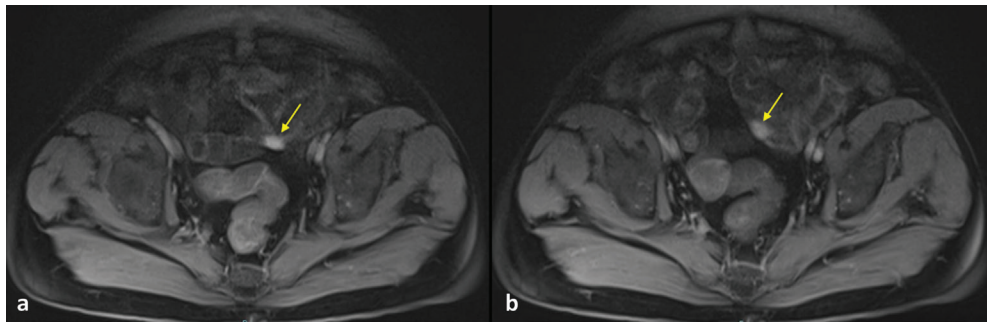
MR enterography, with oral biphasic contrast agent polyethylene glycol (PEG) and Gadolinium by intravenous administration, in the axial plane, with arterial (a) and venous (b) phases. MRI confirmed the presence of the jejunal GIST lesions with exophytic growth and intense enhancement in the arterial phase (a) and wash-out in the venous phase (b).
